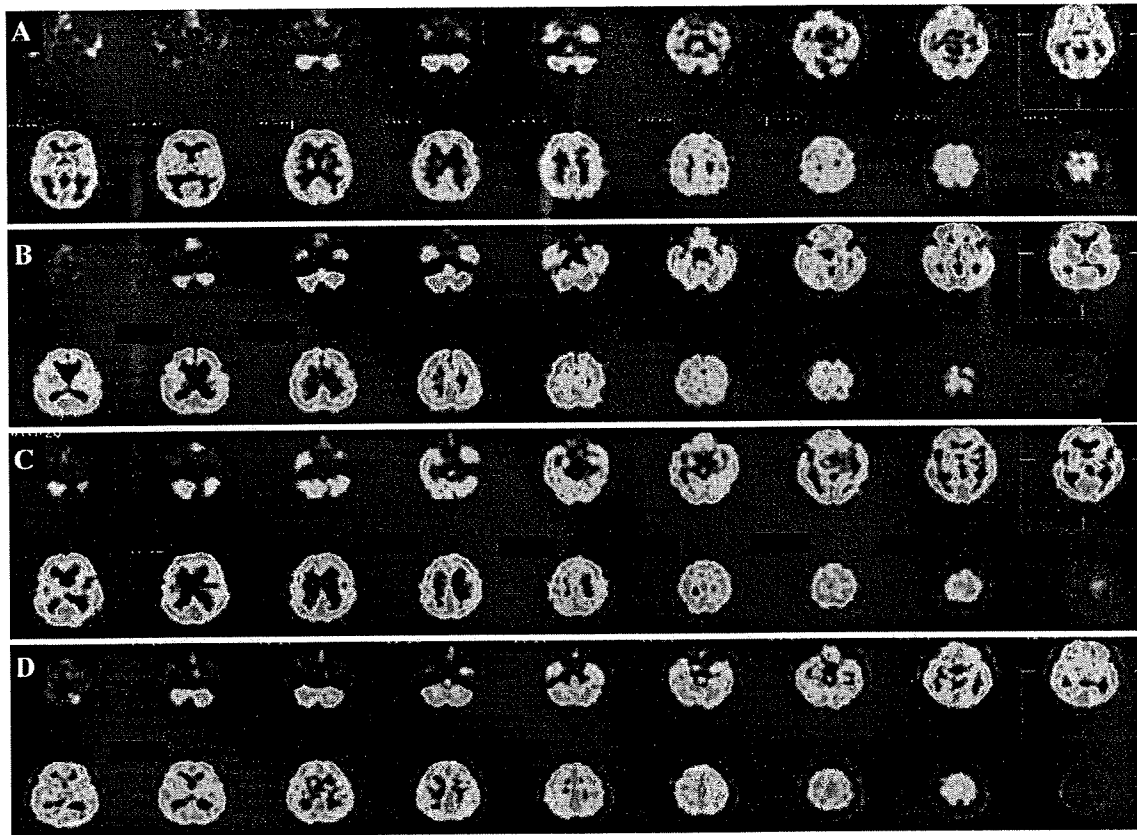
SPECT images (axial view) in patients with LCCA and MSA-C. The significantly decreased rCBF could be detected obviously in medial temporal lobe and cerebellum in patients with LCCA (A), and in medial temporal lobe basal ganglia, cerebellum, and brainstem in patients with MSA-C (C). It is difficult to detect the slightly decreased rCBF by the visual analysis in some patients with LCCA (C) and MSA-C (D). LCCA: late-onset cortical cerebellar ataxia. MSA-C: cerebellar variant of multiple system atrophy.
